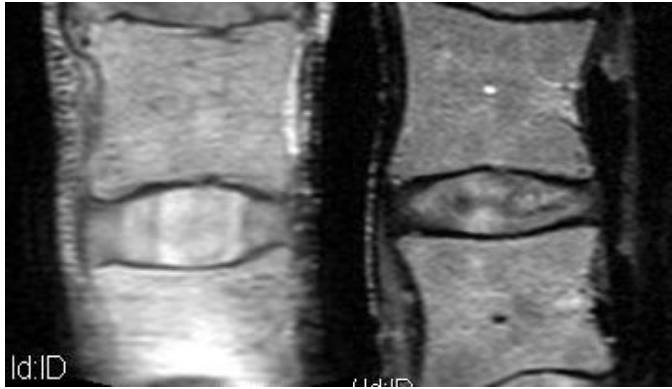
Sagittal MR images of representative healthy (left) and degenerated (right) discs.
